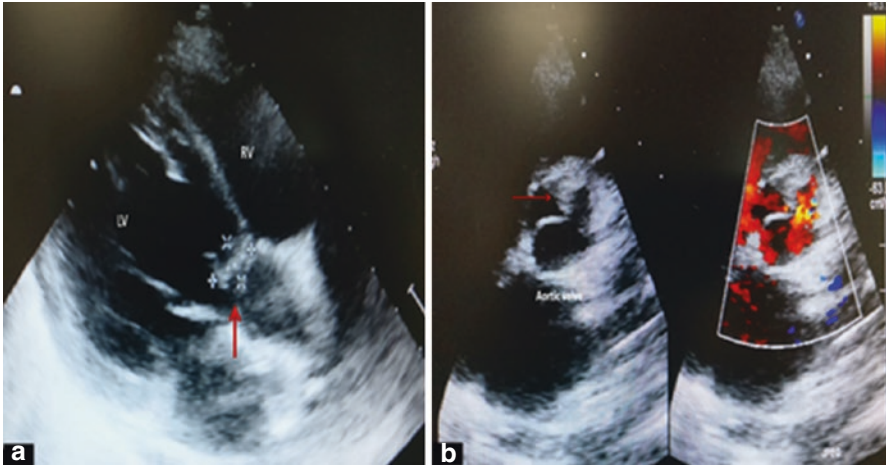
(a) Echocardiogram (parasternal long-axis view) showing vegetation (arrow) in left ventricular outflow tract arising from base of the aortic valve. (b) Echocardiogram (parasternal short-axis view at level of aortic valve) showing vegetation and abscess (arrow) near aortic valve annulus
